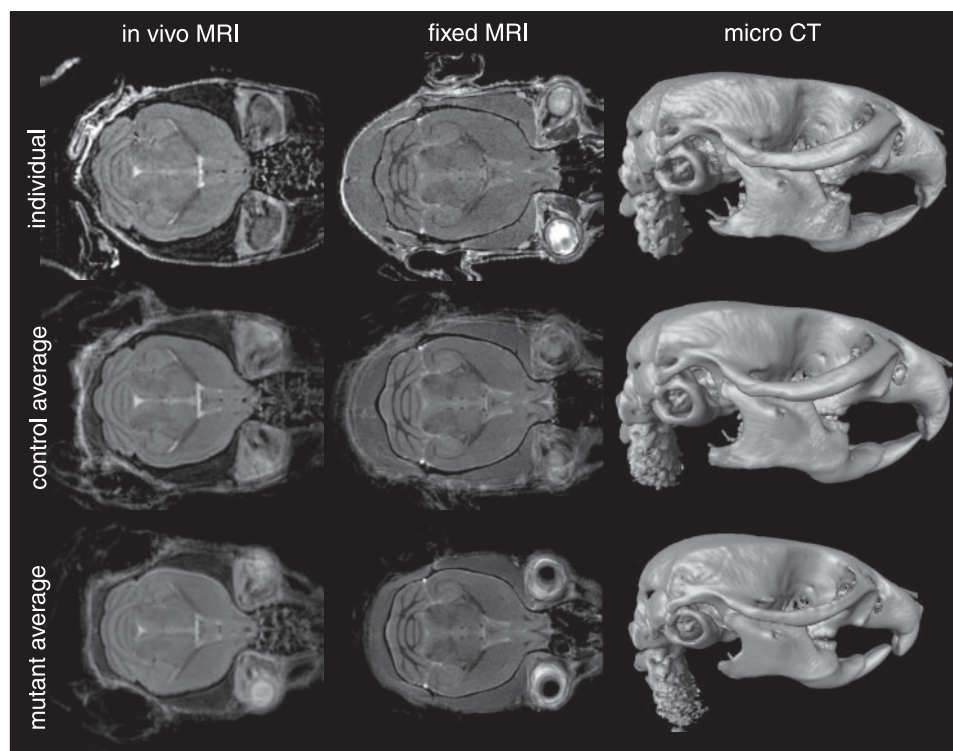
Image acquisition and average image generation results. *Top*: images from a single individual for each of the three imaging protocols. *Middle and bottom*: control (*middle*) and mutant (*bottom*) average images as generated by the protocol given by Kovacevic et al. (25). MRI, magnetic resonance imaging; CT, computed tomography.
